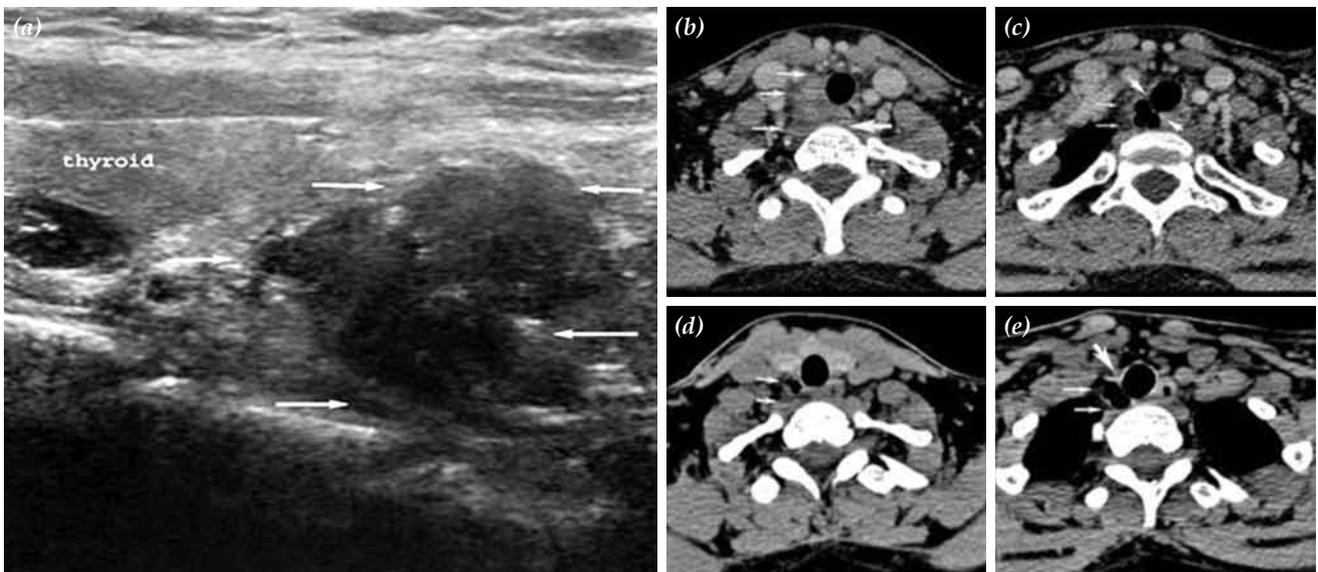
(a) Neck ultrasound demonstrates a heterogeneous hypoechoic mass (arrows) with hyperechoic foci at the inferoposterior aspect of the right thyroid lobe. (b) Neck computed tomography shows a hypodense right paratracheal lesion (arrows) displacing trachea and esophagus (big arrow) to the left. (c) Note the air density within the lesion (arrows) and narrow connection between the lesion and trachea (big arrow). (d, e) On a follow-up computed tomography, most of the lumen of the lesion was filled with air and the infected component had regressed. The tracheal cartilage seems to be in continuity by wall of diverticulum (big arrow).
